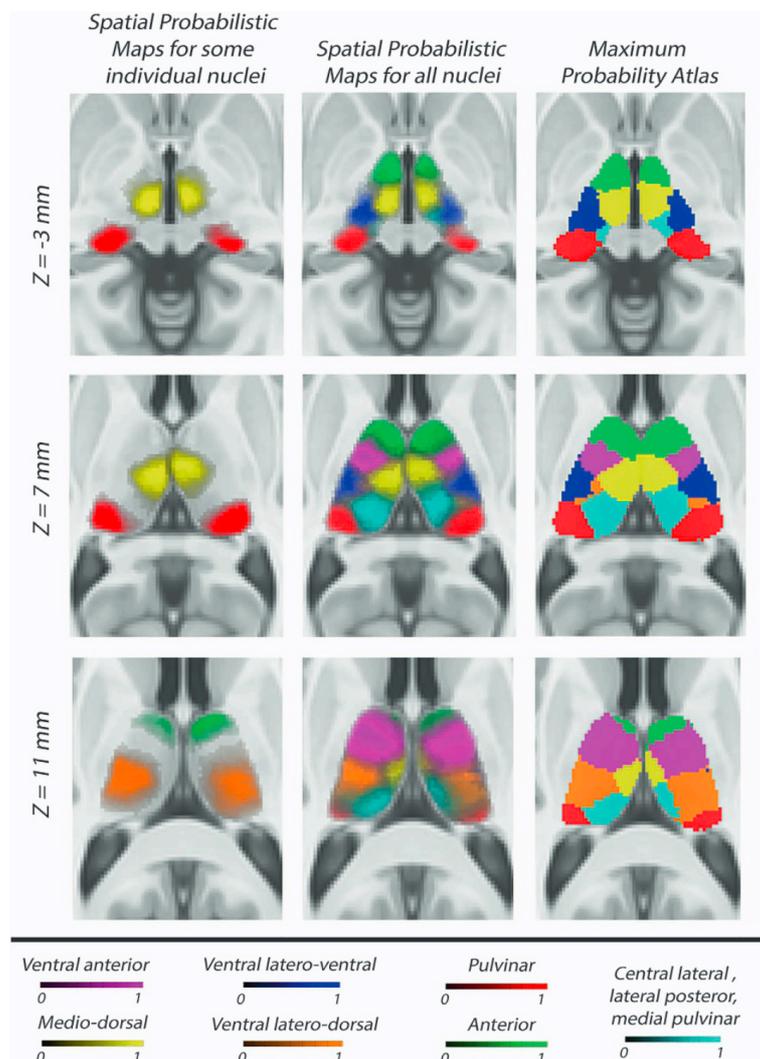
The In-vivo probabilistic atlas of human thalamic nuclei by Najdenovska et al. (2018) provides a segmentation of human thalamus in 7 nuclear areas per hemisphere, based on diffusion-weighted MRI. Depicted are three exemplary slices, which show the overlay with the spatial probabilistic maps (first and second column) and the maximum probability atlas (third column). Figure reproduced under a CC-BY 4.0 license (<http://creativecommons.org/licenses/by/4.0/>), for original see Figure 2 of Najdenovska et al., 2018.
